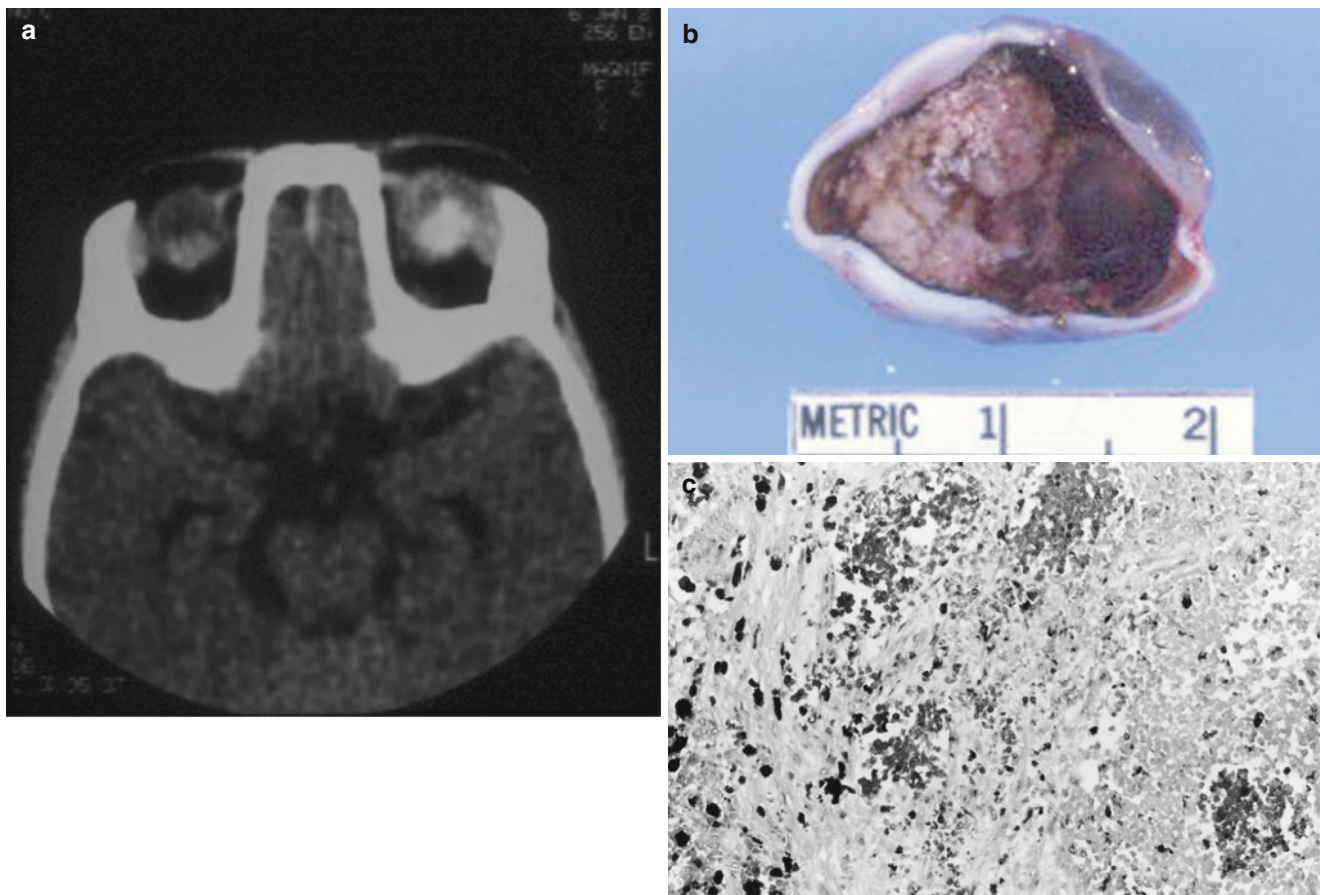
Retinoblastoma with extensive necrosis and calcification. Two-month-old female presented with a swollen left eye several days prior to hospital admission. (a) CT scan reveals bilateral retinal tumors, the left larger than the right. (b) The hemisected left eye shows necrotic
